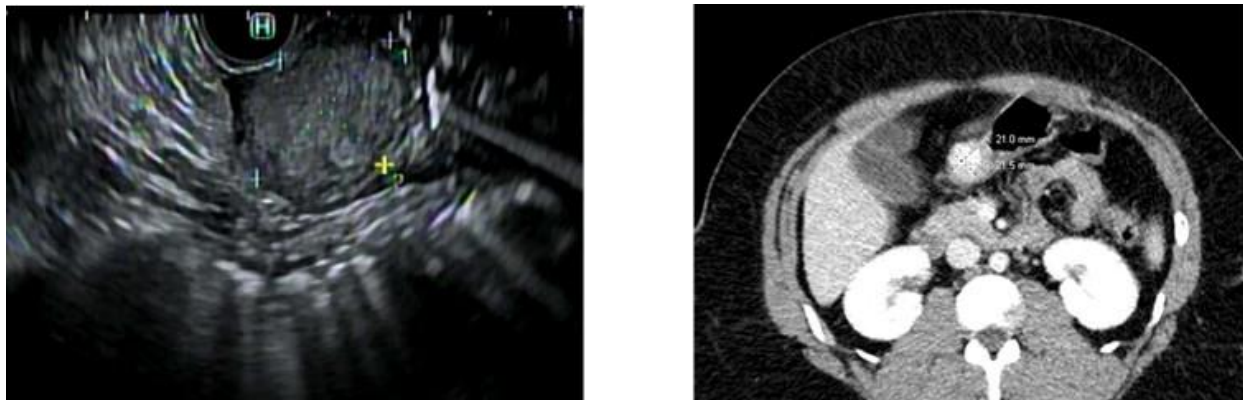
Endoscopic images show an intramural (subepithelial) mass in the lesser curve of the stomach, which appeared to originate from within the muscularis propria (A). Abdominal CT scan with contrast show avidly enhancing submucosal mass arising from the inferior aspect of the antrum of the stomach (B).
